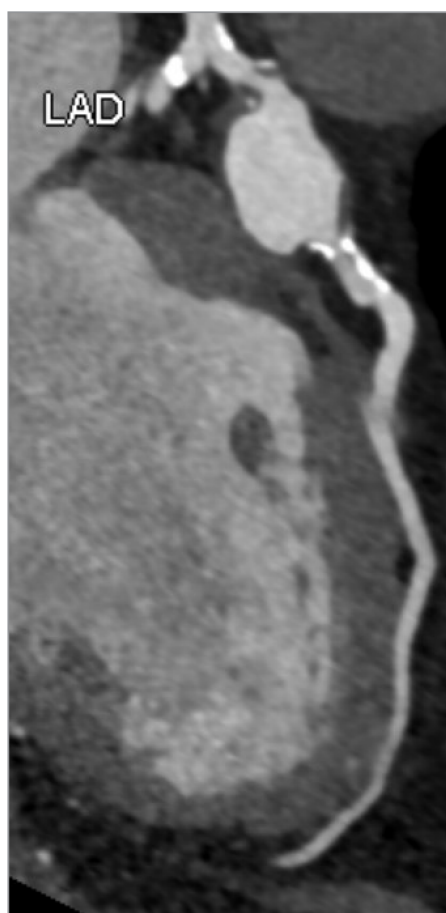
Preprocedural coronary computed tomography angiography outlines the left anterior descending coronary artery (LAD) aneurysm.
